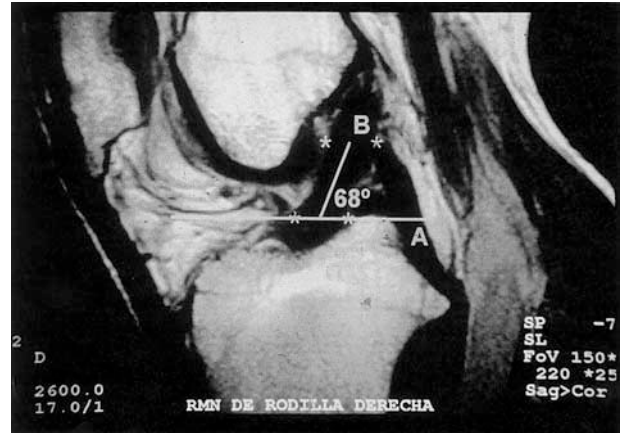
Sagittal MRI from case number 19 at 36 months after reconstruction. The relationship of the ACL graft to the tibial plateau was studied according to the following landmarks: A tibial plateau line (A) was drawn perpendicular to the long axis of the tibia at the level of the anterior edge of the ACL graft insertion. The anterior-most portion of the ACL graft was marked at line A and at the midpoint between the origin and insertion. The posterior edge of the ACL graft was also marked at the line A and again, at the midpoint between the origin and insertion. Second line (B) was drawn following the mid distance between these anterior and posterior ACL graft landmarks. Obliquity of the grafted ACL was determined by measuring the intersection between lines A and B.
